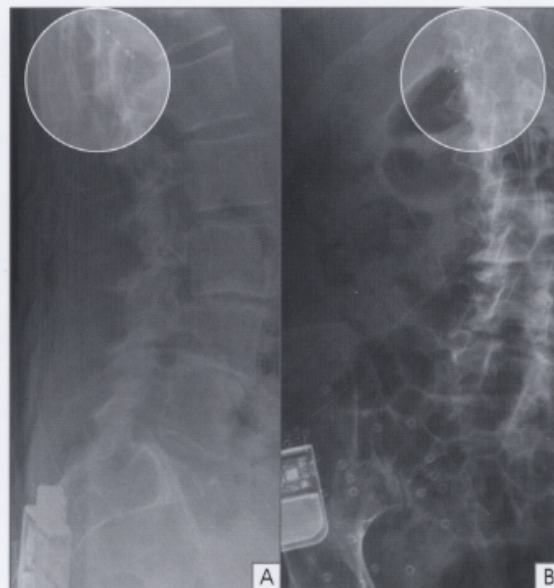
Patient 2 X-rays of implanted neurostimulation system for SCS of the DRG. (a) Lateral and (b) anterior views.
